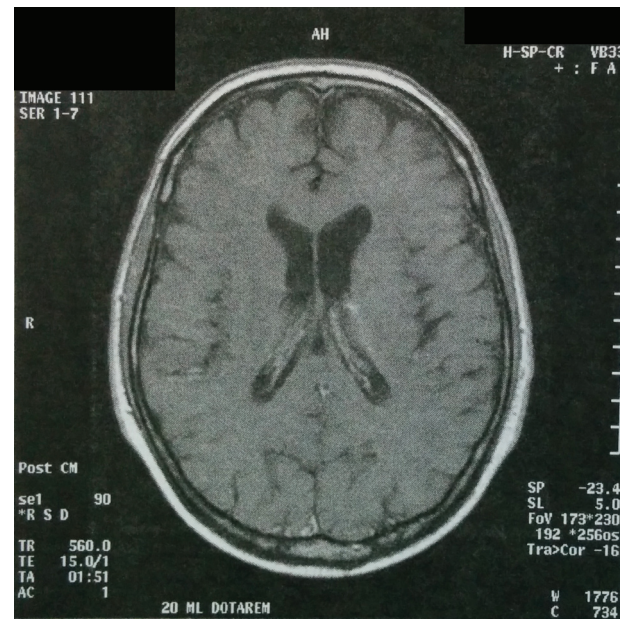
After 15 days on vancomycin/meropenem, a new brain MRI showed almost complete resolution of the ring-enhanced lesions.
